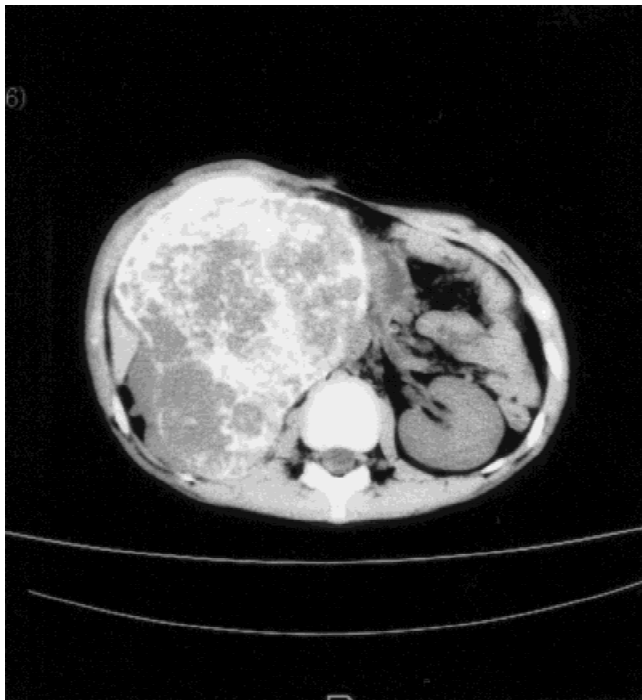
CT shows a retroperitoneal huge solid mass with speckled calcification, maximum diameter 16 cm, occupying the right flank and pushing the kidney upward.
